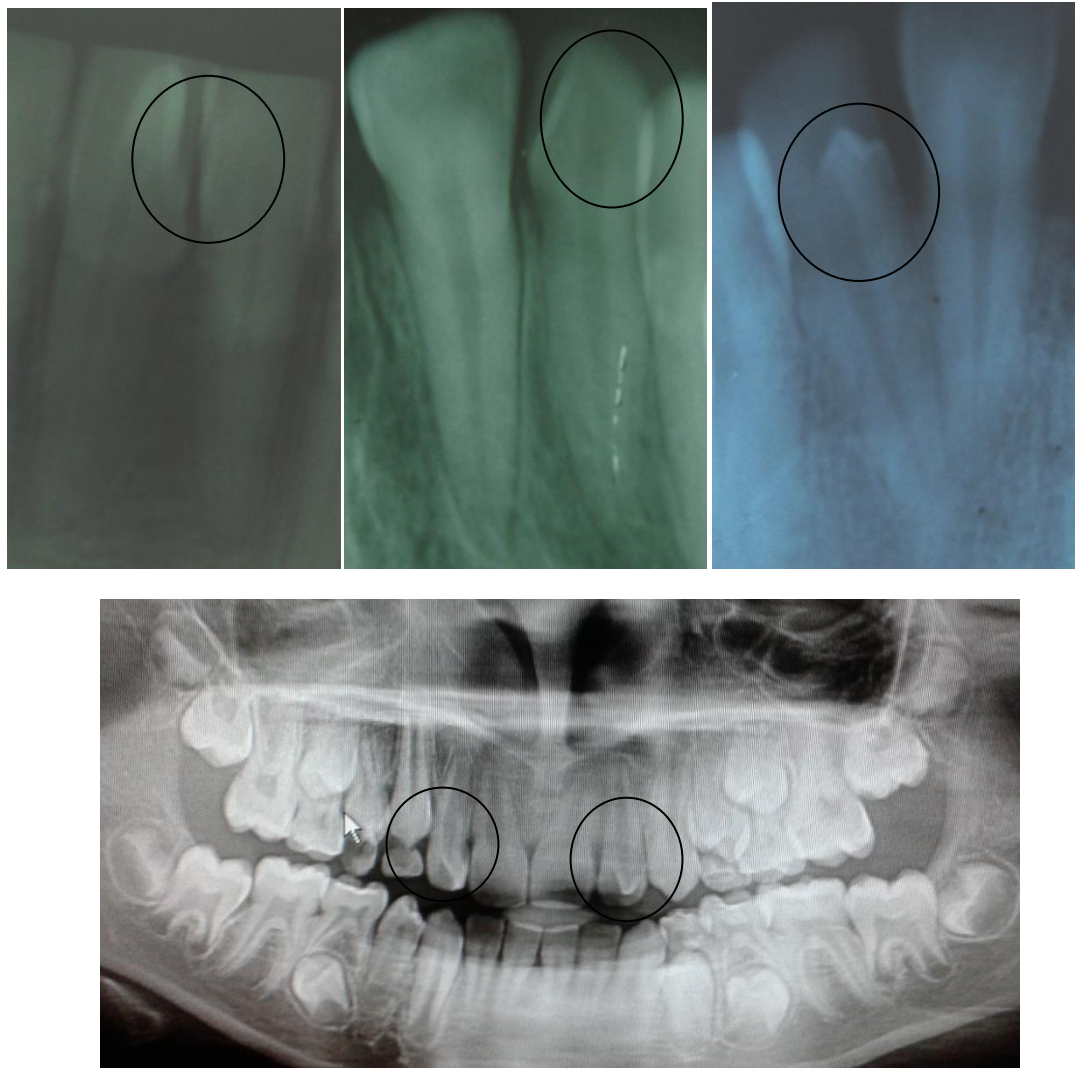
Radiographic appearances of Talon cusps
